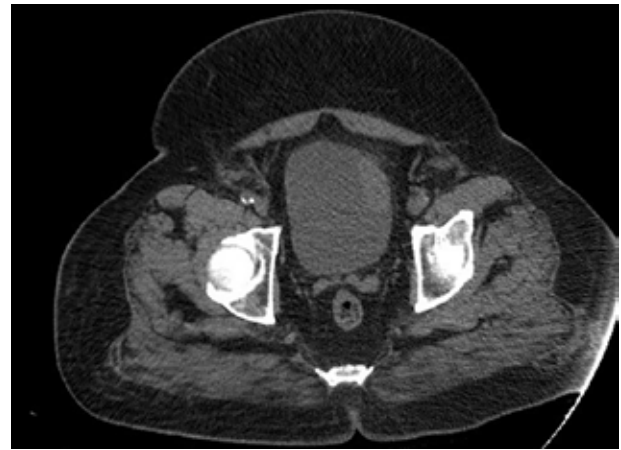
Computed tomography showed 4 x 3 cm polypoid mass at the left bladder wall.
